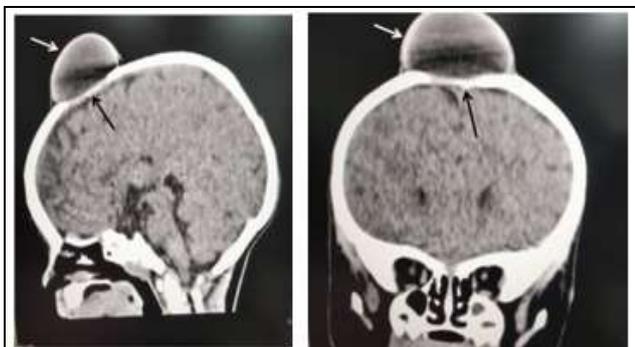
Plain CT Brain - Sagittal and Coronal Sections Show Well Defined Cystic Lesion (White Arrow) in Midline High Frontal Region at the Confluence of Coronal and Sagittal Sutures (Black Arrow) - Dermoid Cyst
